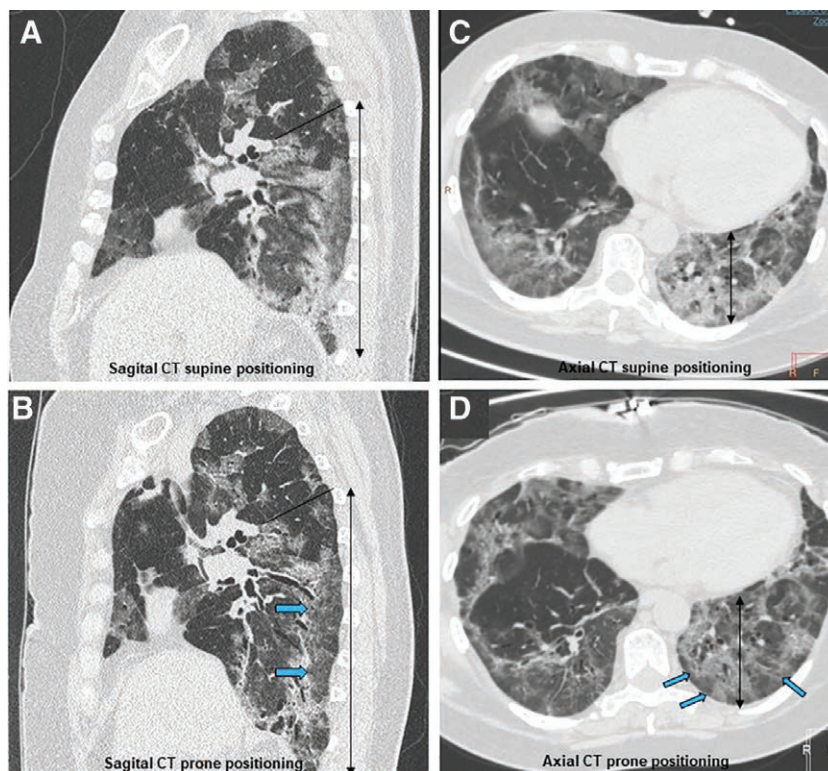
Chest computed tomographic image of an awake 71-yr-old patient with pneumonia by COVID-19 in supine (*A* and *C*) and prone positioning (*B* and *D*). Sagittal computed tomography (*A* and *B*) shows a slight decrease in attenuation of some of the lung lesions in prone study (*blue arrows*) and an increase in lung volumes of the right lower lobe (*black arrow*; *B*) compared with the supine study (*A*). Axial computed tomography (*C* and *D*) shows an increase in lung volumes of the left lower lobe (*black arrow*) with decrease in attenuation in the prone study (*blue arrows*; *D*) compared with the supine study (*C*). The prone studies (*B* and *D*) show a partial recovery of the aerated lung parenchyma in the left (*B*) and right (*D*) inferior lobe.
